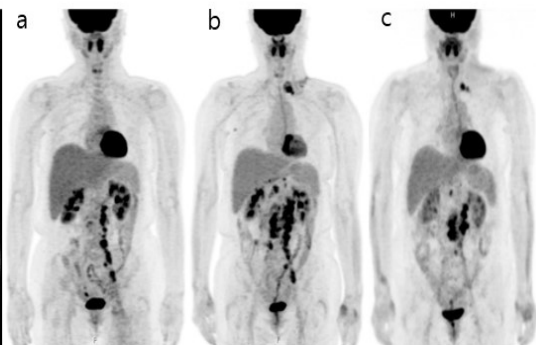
PET-CT. Initial PET-CT (a) showed enlarged lymph nodes in multiple regions. Images (b) after four month of "Watchful waiting" showed worsening lymphadenopathy and new lymphadenopathy in other regions. Images (c) after 13 cycle of chemotherapy showed improving lymphadenopathy.
